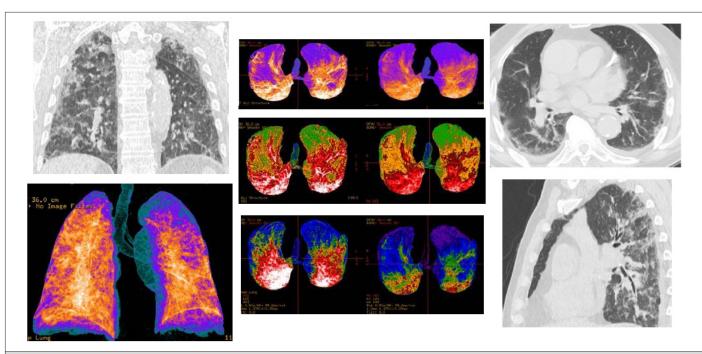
CT patterns of extended bilateral Covid-19 pneumonia of a 80-year-old male patient. MPR (axial, coronal, sagittal) reconstructions showed: bilateral and multifocal typical "ground-glass" areas; bilateral interstitial thickenings, with some consolidations areas; bi-basal pleural effusion. In the Volume Rendering (VRT) "colored" reconstructions, the blue areas represented the normal lung parenchyma (also in the ventral and dorsal areas), while orange/white and red areas indicate the inflammatory pulmonary involvements, with consolidations.
